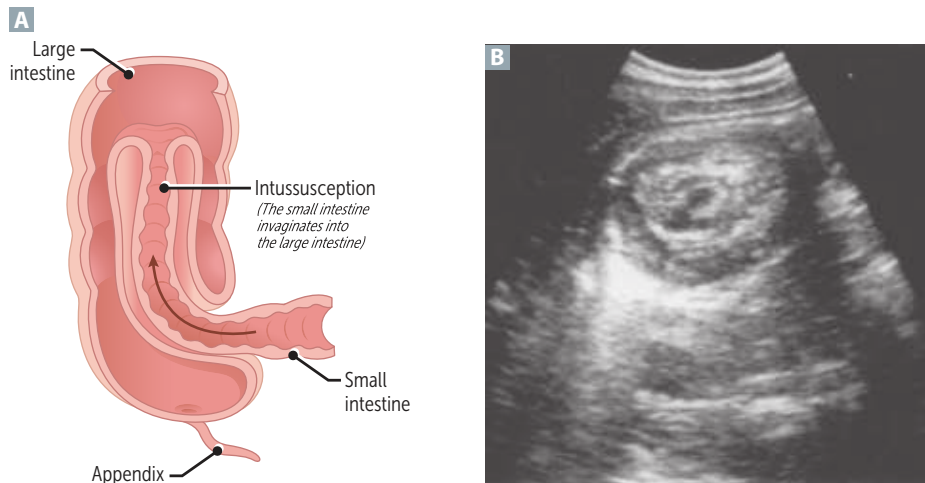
Intussusception. (A) Ileocolic intussusception, the most common location in children. (B) Transabdominal ultrasound showing the classic “target sign” of intussusception in cross-section. (Image A reproduced with permission from USMLE-Rx.com. Image B reproduced with permission from Ma OJ et al. *Emergency Ultrasound*, 2nd ed. New York, NY: McGraw-Hill; 2008.)
